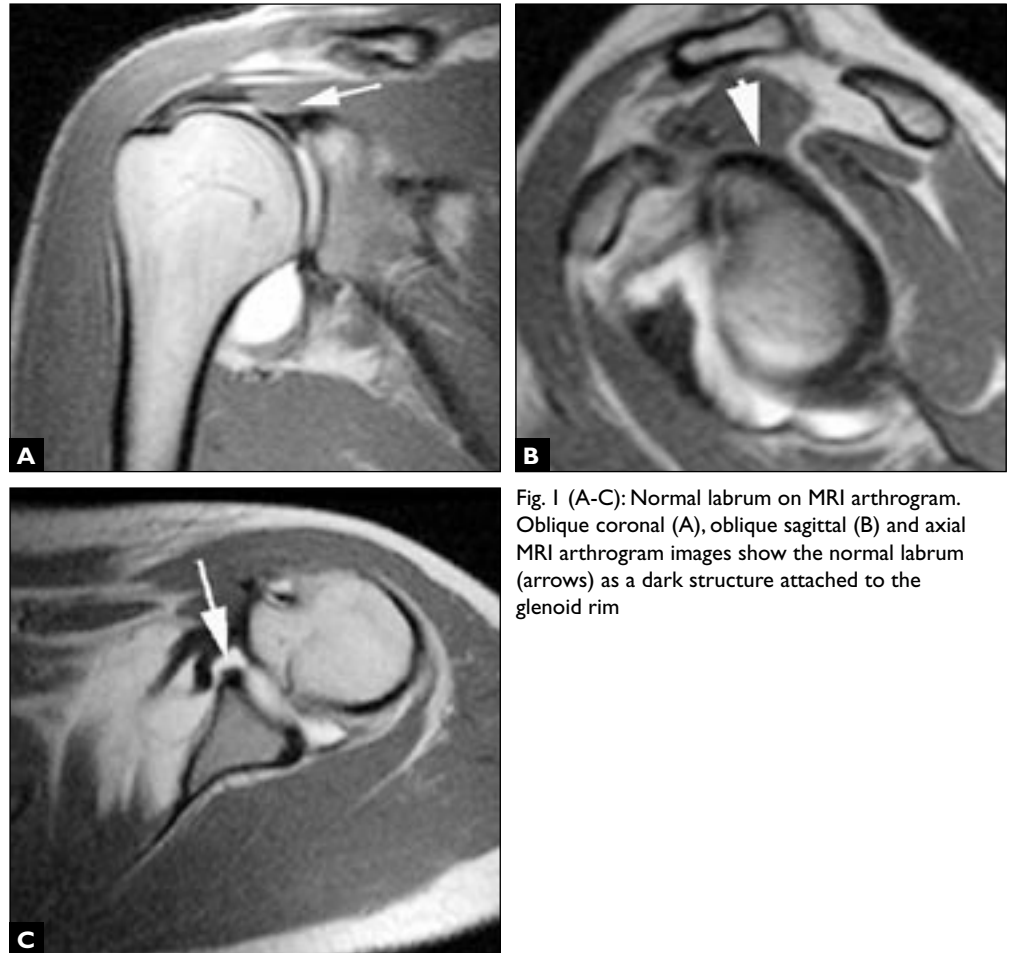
(A-C): Normal labrum on MRI arthrogram. Oblique coronal (A), oblique sagittal (B) and axial MRI arthrogram images show the normal labrum (arrows) as a dark structure attached to the glenoid rim
